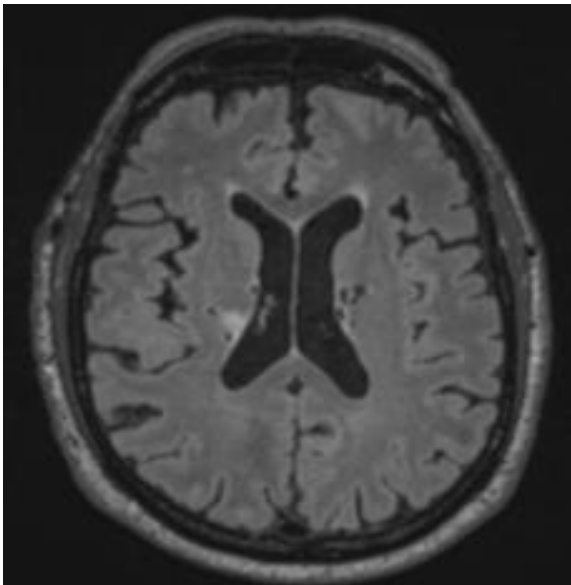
Examples of brain scan images of microbleeds, WMH, and lacunes, using different MRI sequences.*
